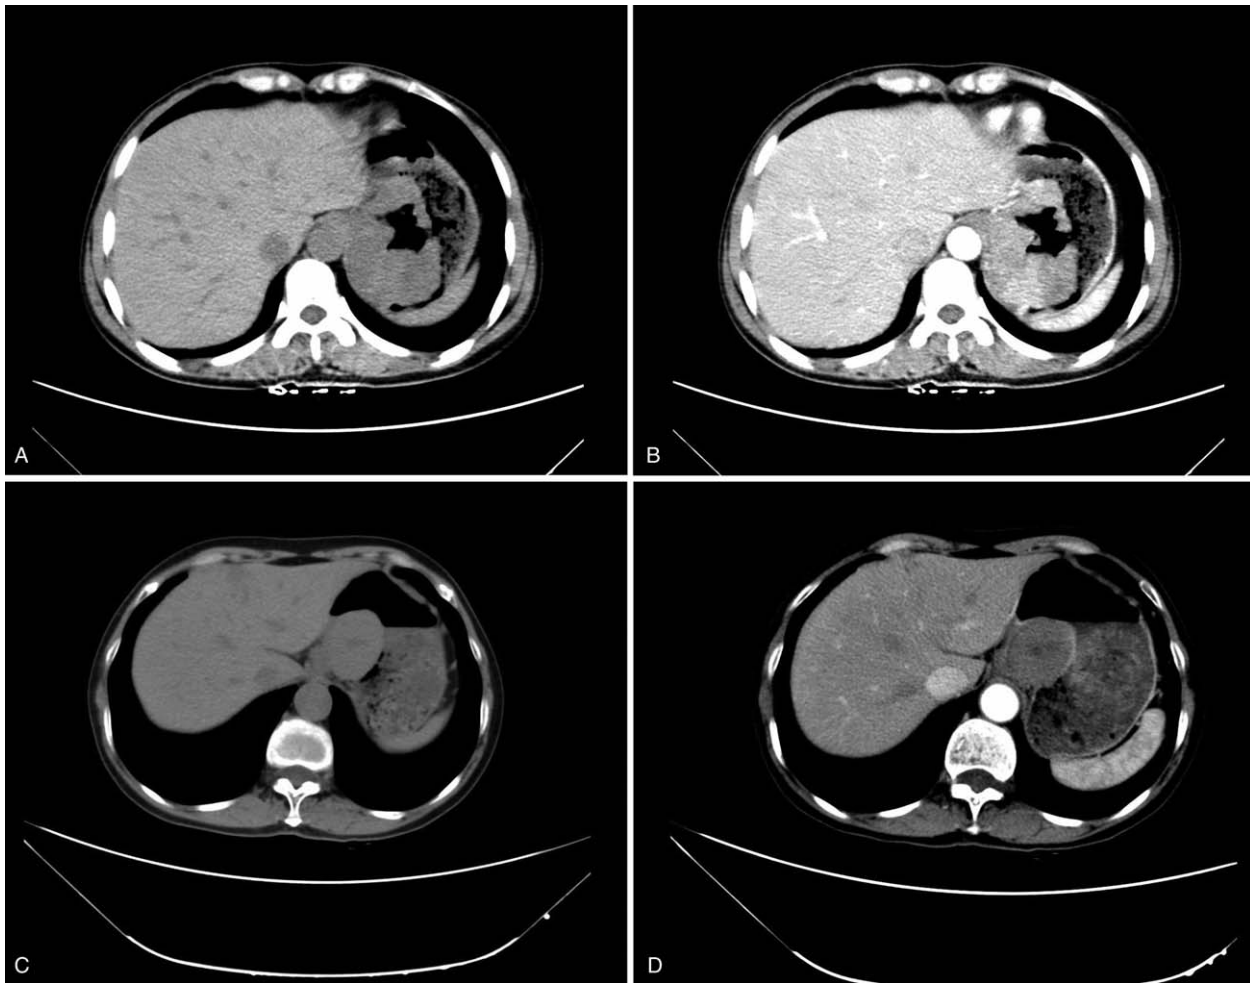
GIST in the esophagogastric junction. (A, B) 47-year-old man with an 8.5-cm GIST in the esophagogastric junction. CT images show heterogeneous enhancement, high degree enhancement, surface ulcer, higher CT attention value (135.7 HU, >69.2 HU), absence of calcification and intralesional low attention. A score of 7 was assigned. (C, D) 59-year-old woman with a 5-cm GIST in the esophagogastric junction. CT images show heterogeneous enhancement, high degree enhancement, intralesional low attention, lower CT attention value (67.8 HU, ≤69.2 HU), absence of calcification and surface ulcer. A score of 6 was assigned.
